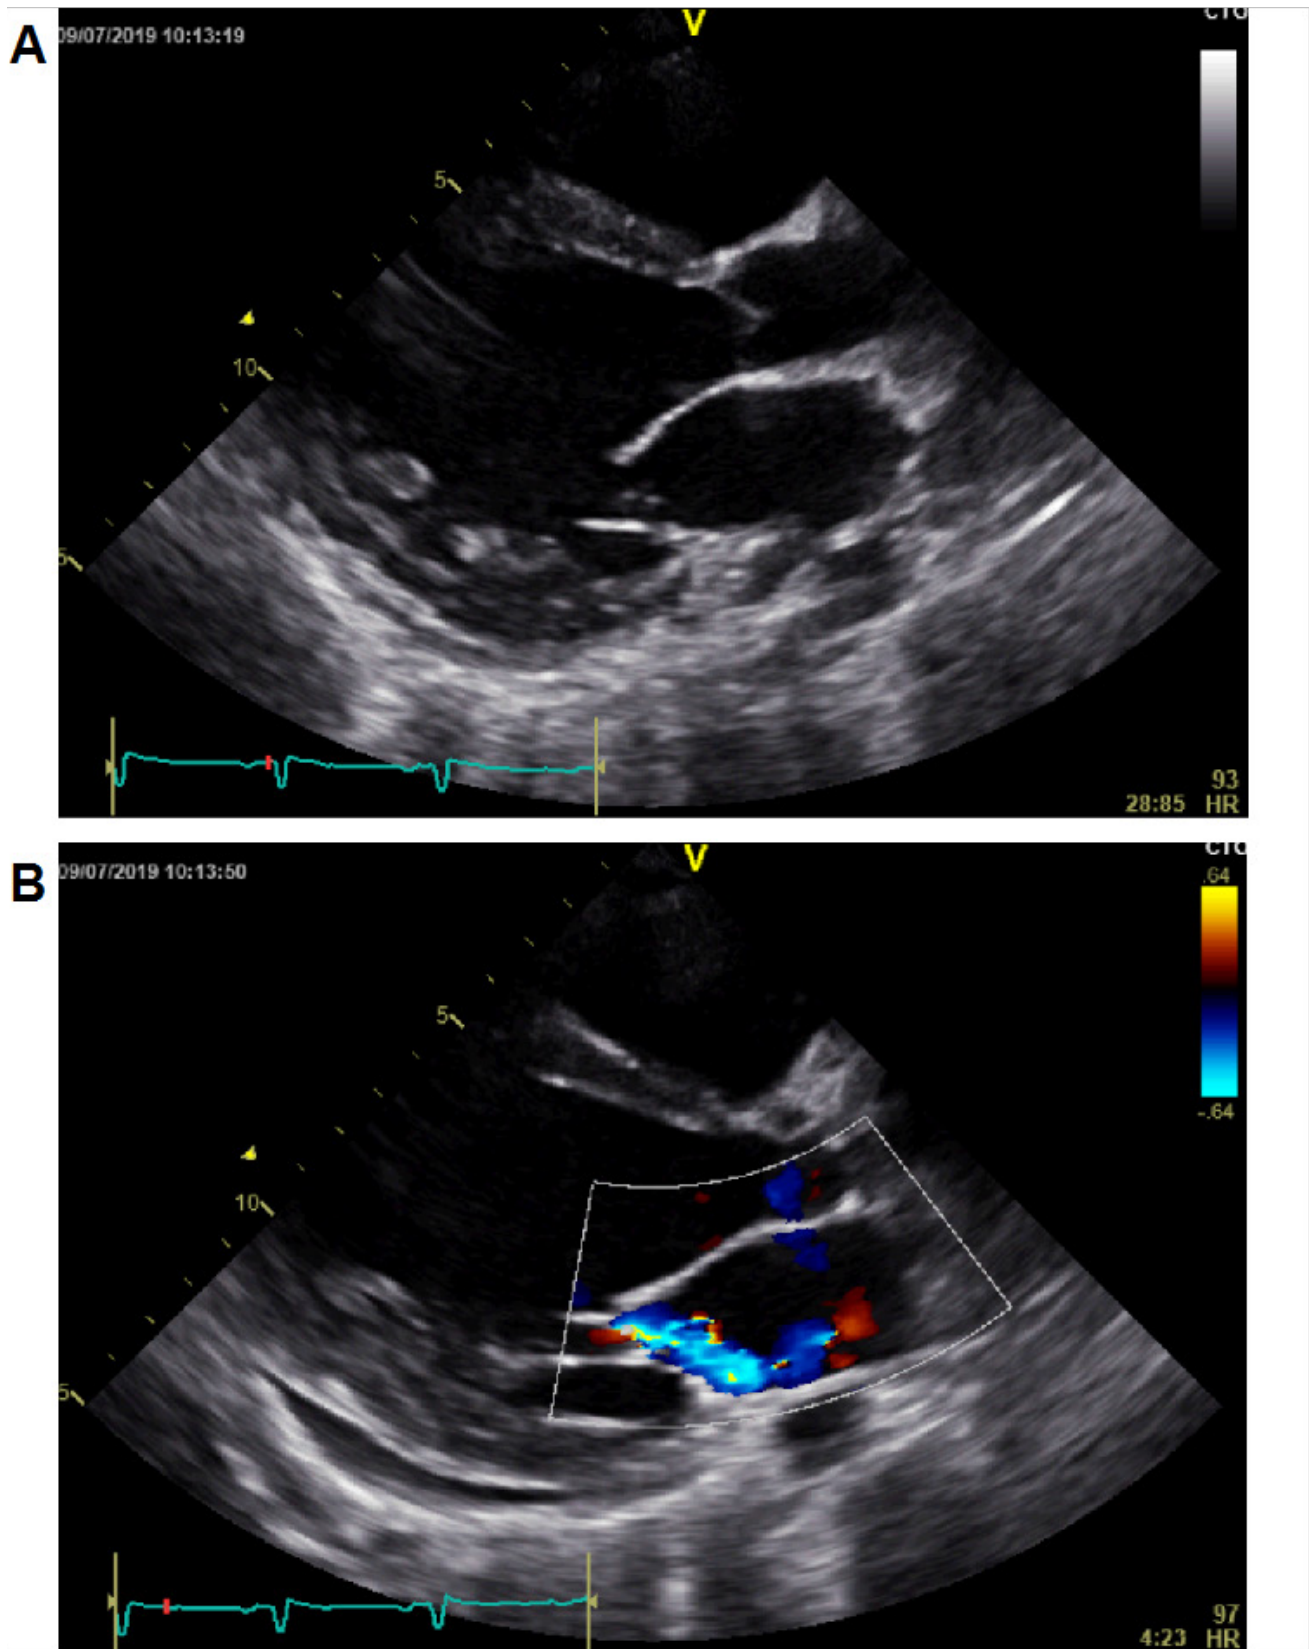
Transthoracic echocardiography of a patient with peripartum cardiomyopathy. Parasternal long axis (PLAX) view showed (A) a dilated left ventricle (LV) with poor systolic function (B) and secondary mitral regurgitation on colour flow Doppler.
